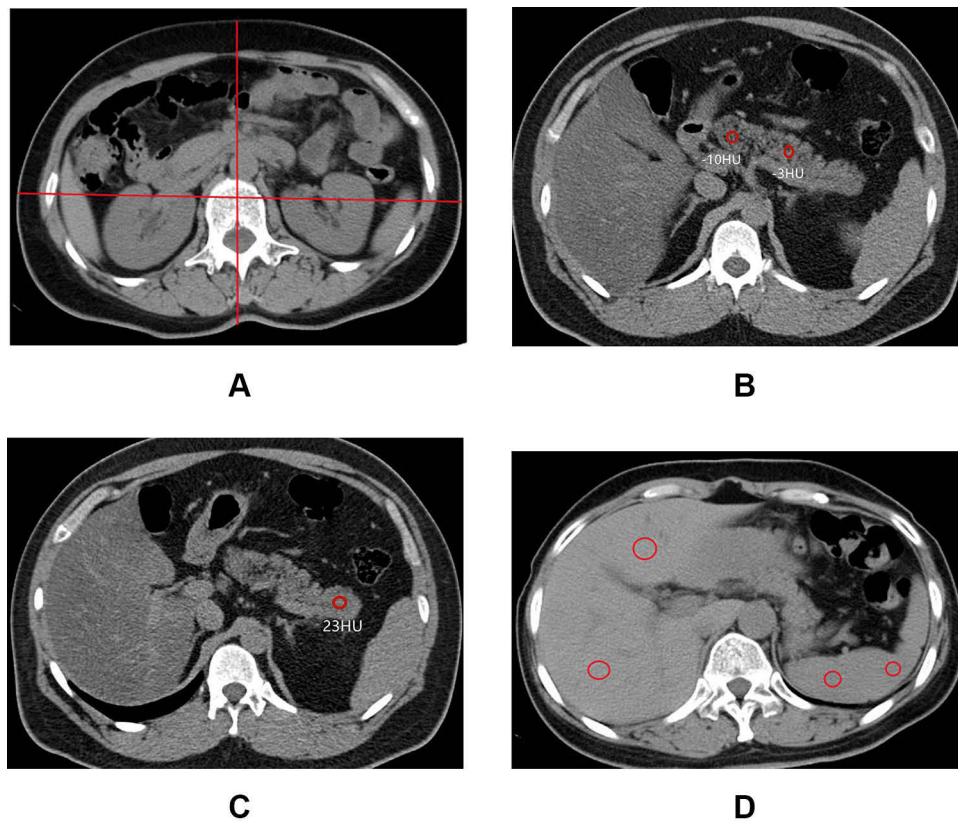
(A) Body width measurement; (B and C) are CT values of the pancreatic head, body, and tail to obtain the mean CT value of the pancreas; (D) is the measurement of CT values of the liver and spleen to obtain the mean CT value of the liver and spleen.
